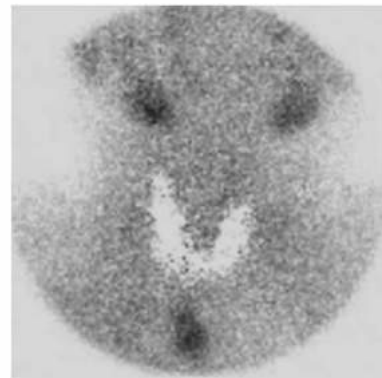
• Parathyroid Tc-99m sestamibi scintigraphy; subtraction protocol. The subtraction image demonstrates a right parathyroid adenoma below the inferior pole of the thyroid lobe.
